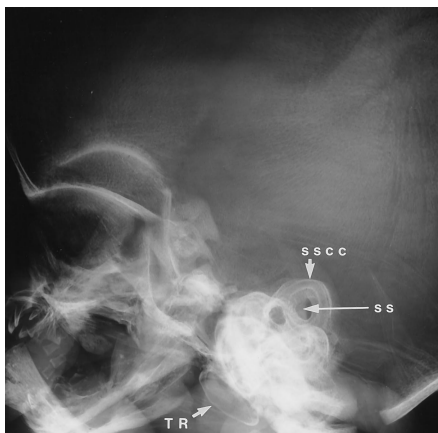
Fetus, gestational age 22 weeks 3 days. Lateral plain radiograph of the skull shows a large subarcuate space beneath the superior semicircular canal. The tympanic ring is an ossified horizontal structure that is separated from the squamous temporal bone.
